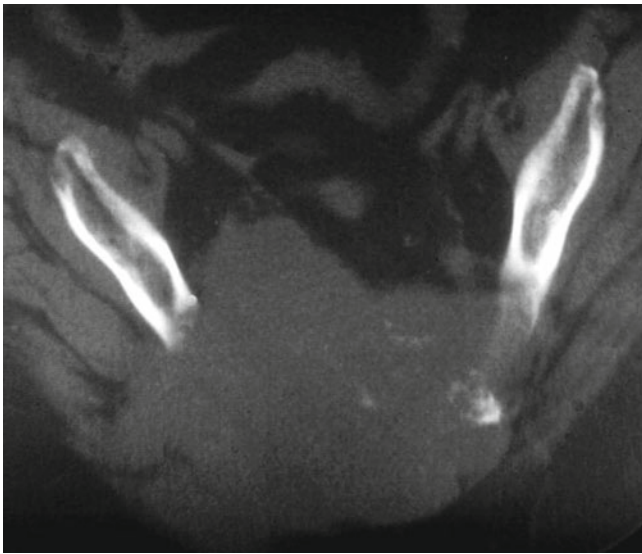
Axial CT scan image showing extensive sacral bone destruction due to chordoma. Note that the tumor is a midline tumor, which can differentiate it from other sacral tumors
